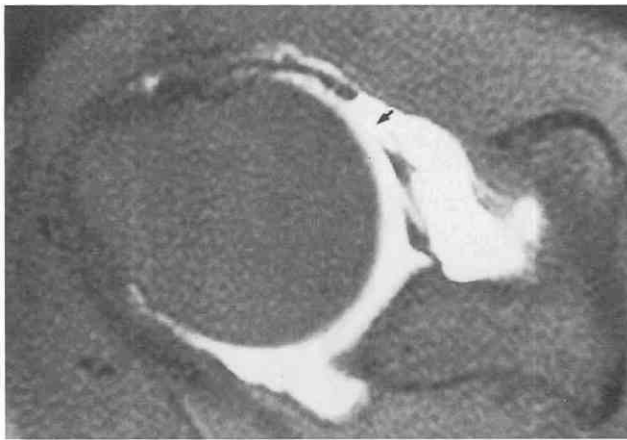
Humeral avulsion of the glenohumeral ligaments (HAGL lesion). T1-weighted (TR = 500 msec, TE = 14 msec), fat-saturated axial MR arthrogram image. A tear in the anterior capsuloligamentous complex is clearly visible (arrow) near its insertion on the humerus. Whether the tear is close enough to the humerus to constitute a true HAGL lesion is debatable.
